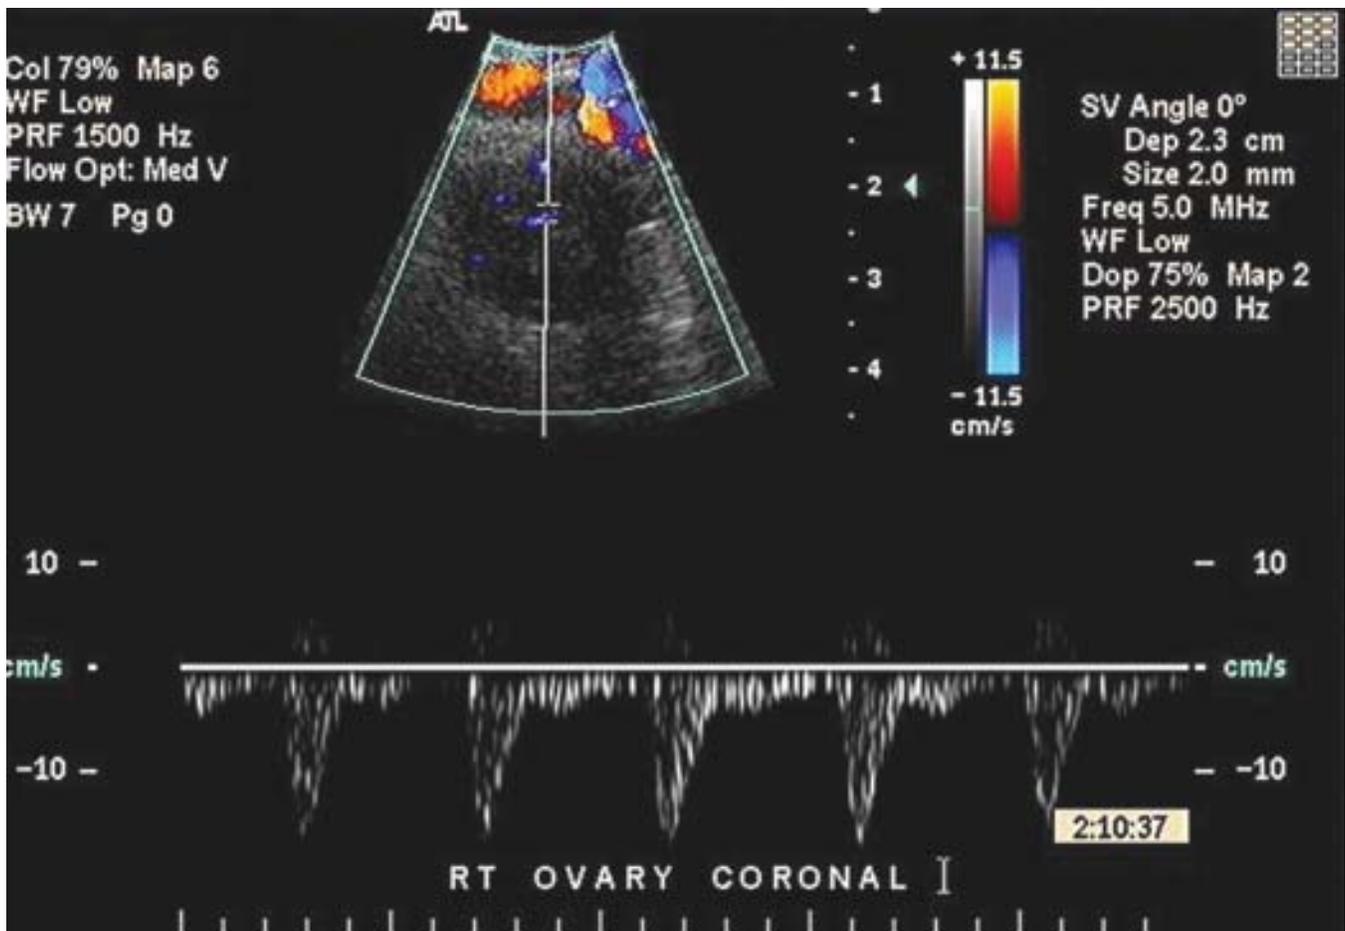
The ovarian artery color and pulsed Doppler. Note the high resistance to blood flow
